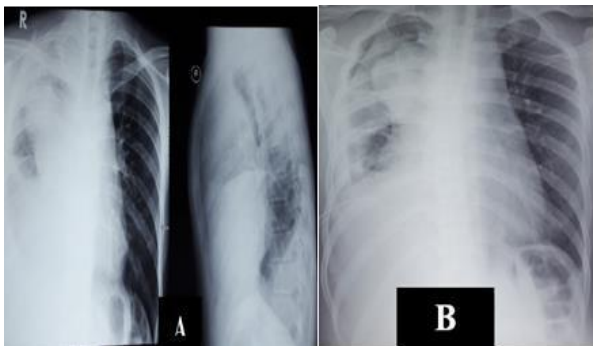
(A) Pre-chest tube thoracic x-ray (B) Post-chest tube thoracic x-ray
